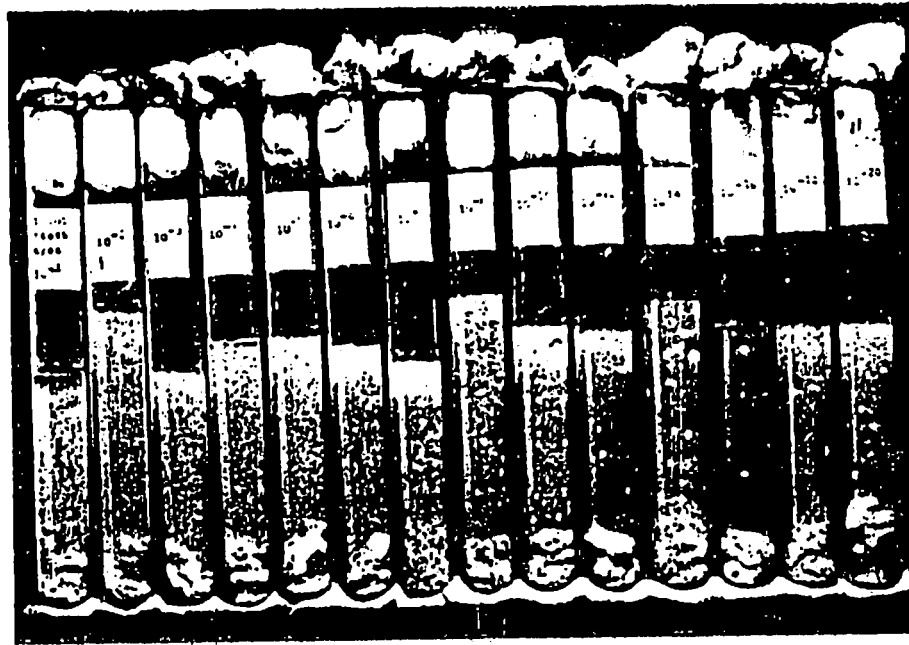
Serial dilution culture of the washings of the apex of an extracted tooth appearing normal in the roentgenogram, in soft (0.2 per cent) dextrose brain agar. Note the diffuse growth in the first two dilutions, innumerable colonies in the next two dilutions and a progressive diminution in the number of colonies of streptococci, with six colonies in the  $10^{-10}$  dilution ( $\times \frac{1}{2}$ ).
